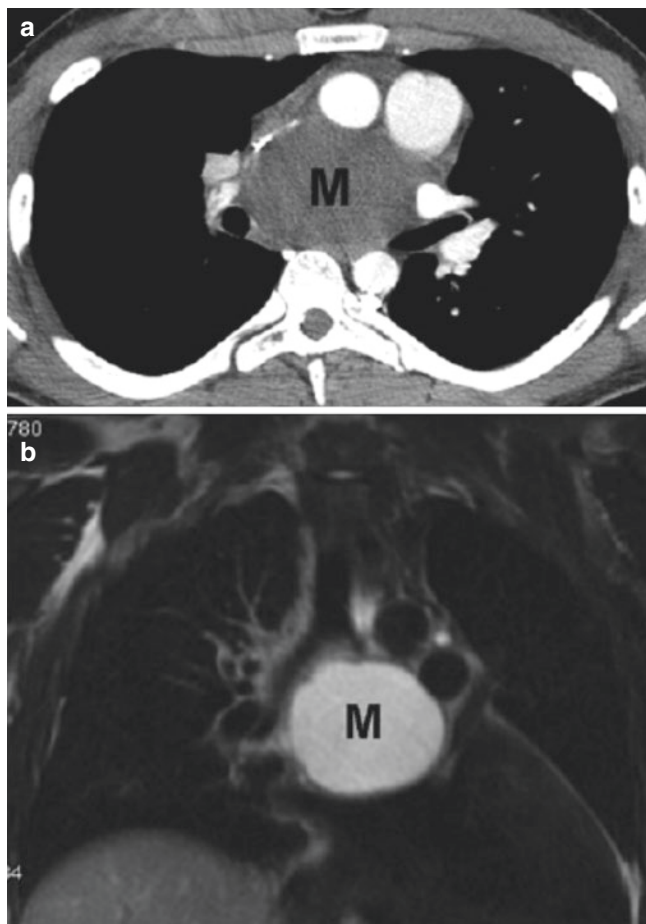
An 18-year-old male with chest pain and respiratory distress. Surgical pathology of the mediastinal cystic mass was consistent with bronchogenic cyst. (a) Enhanced axial CT image shows a large round cystic mass (M) located in the subcarinal region. (b) Coronal T2-weighted MR image demonstrates a large round cystic mass (M) with high MR signal intensity
